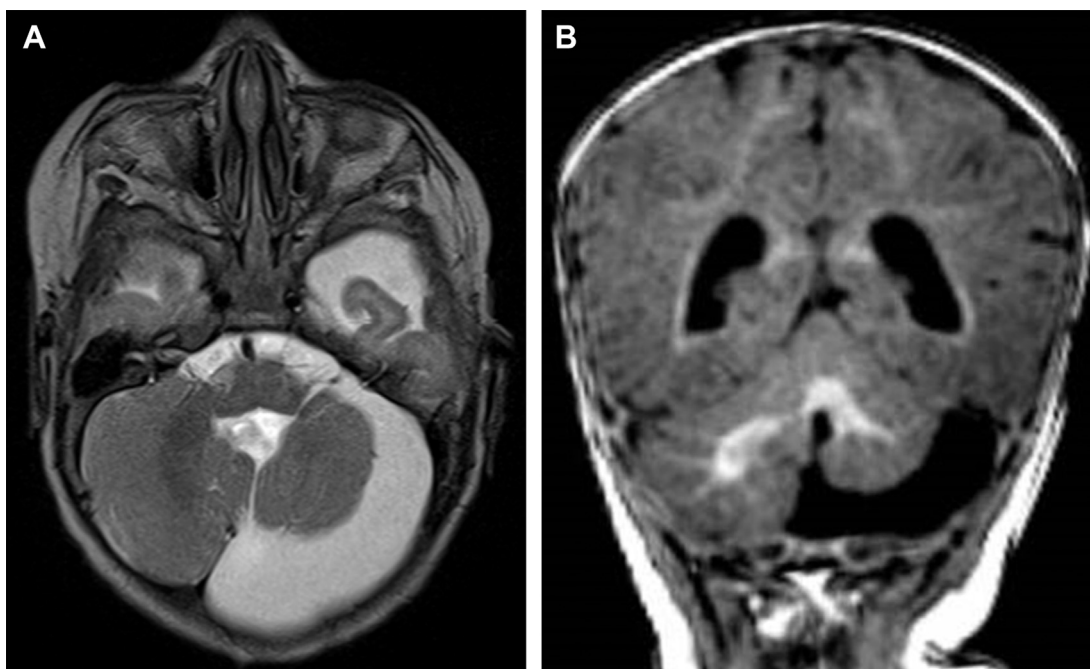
4-month-old girl with PHACE syndrome. (A) Axial T2 and (B) coronal T1-weighted images showing unilateral cerebellar hypoplasia with volume loss in the left cerebellar hemisphere and vermis with a normal sized posterior fossa and a prominent extra-axial CSF space subjacent to it.
